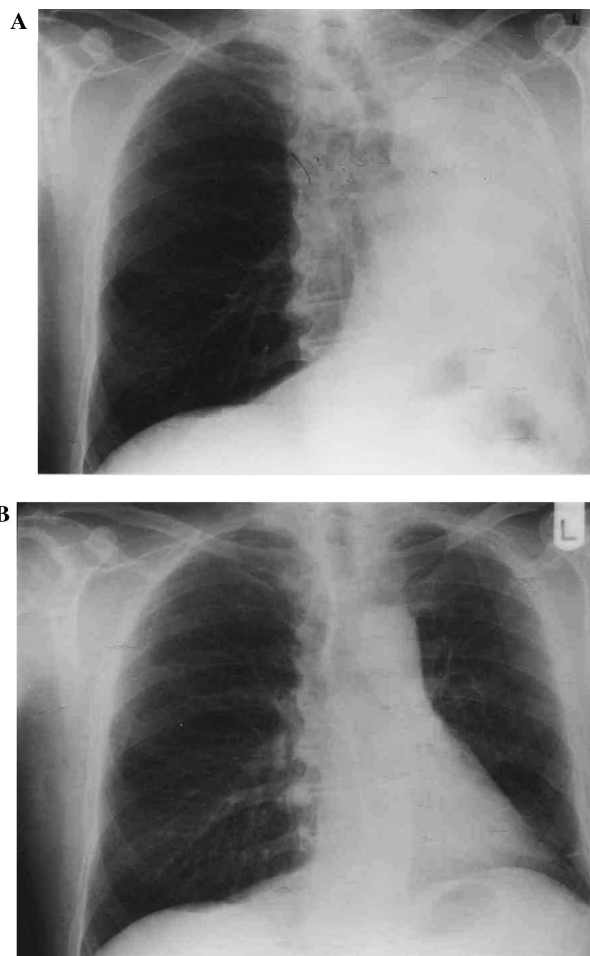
Chest X-rays for a patient A with complete blockage of right lung and re-expansion following cryosurgery.
